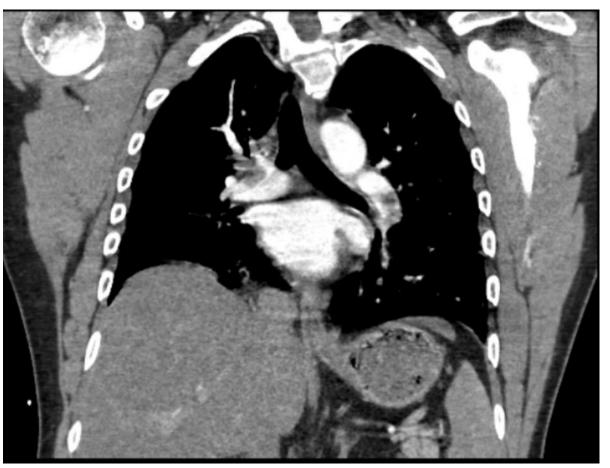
CT Chest showing bilateral pulmonary emboli in the distal right pulmonary artery and left interlobar artery.
